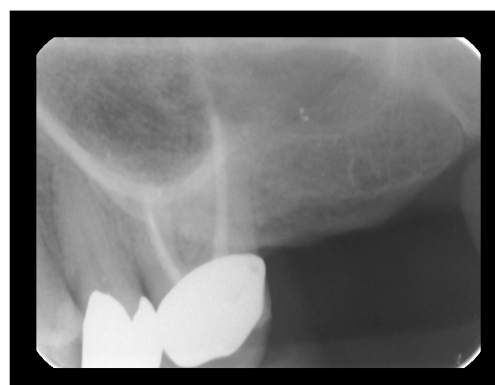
Follow up radiograph
